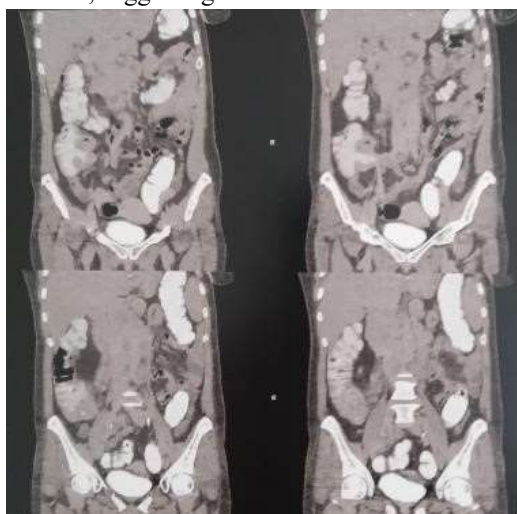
Abdominal and pelvic CT scan in coronal sections Polypoid formation extending over 6 cm in the cecal area, with deep coeliomesenteric, interaortocaval, and left lateroaortic lymphadenopathies measuring 1 to 2 cm.
